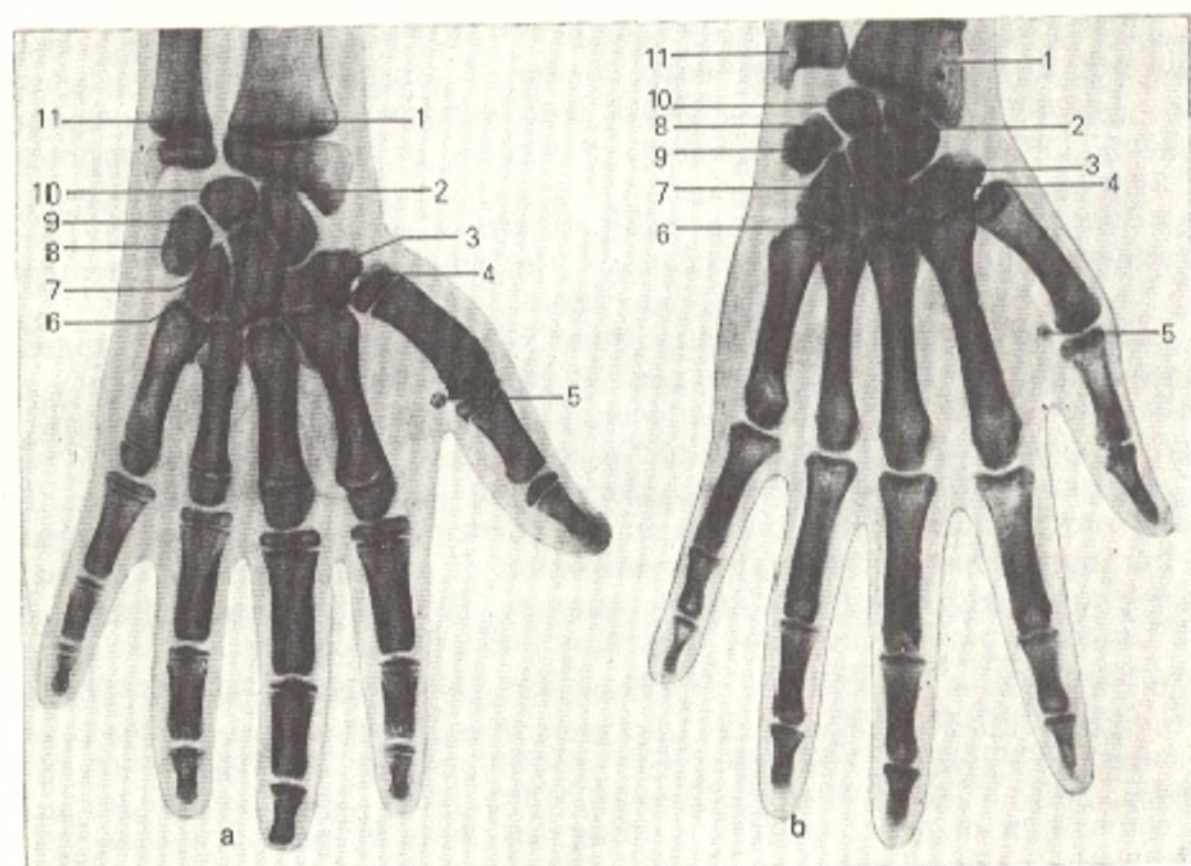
Radiograph of the hand.
